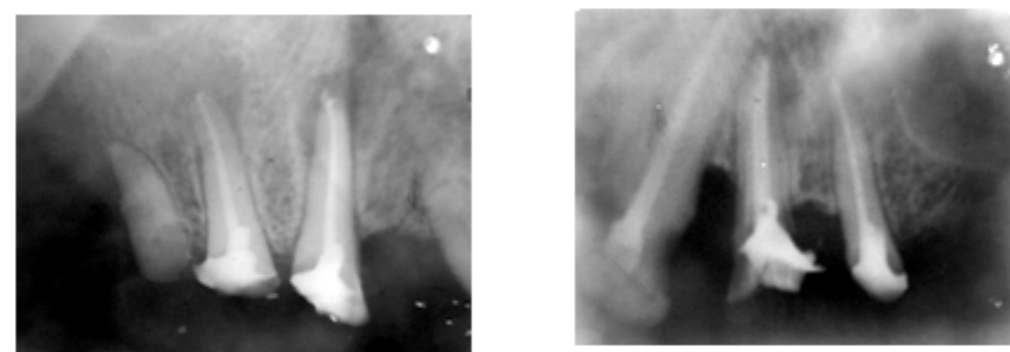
Radiograph of broken down teeth
